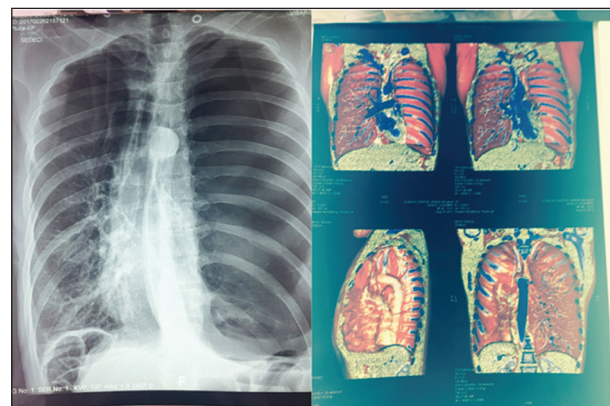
Chest X-ray with extensive bullous disease in the left lung, occupying more than 95% of the hemithorax.
